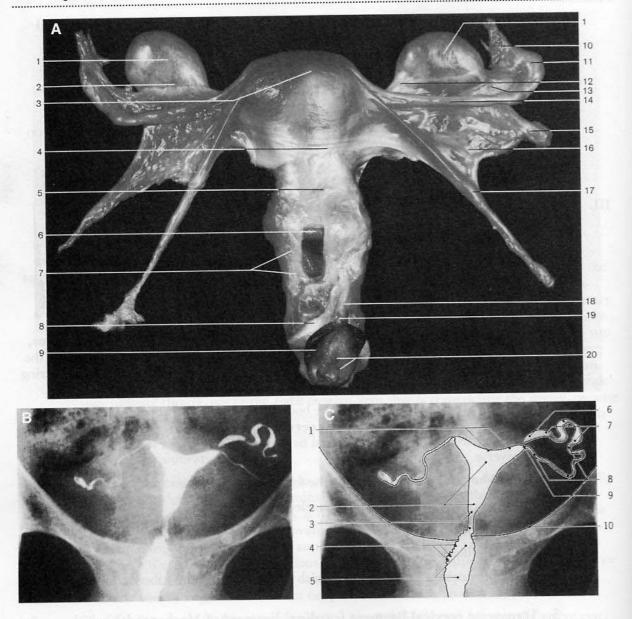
(*A*) Anterior view of the female genital organs, with the anterior wall of the vagina opened to show the cervix. 1 = ovary; 2 = mesovarium; 3 = fundus of the uterus; 4 = vesicouterine pouch; 5 = cervix; 6 = vaginal part of the cervix; 7 = vagina; 8 = crus of the clitoris; 9 = labium minus; 10 = infundibulum of the uterine tube; 11 = ampulla of the uterine tube; 12 = ovarian ligament of the uterus; 13 = mesosalpinx; 14 = uterine tube; 15 = suspensory ligament of the ovary (caudally displaced); 16 = broad ligament; 17 = round ligament of the uterus; 18 = corpus cavernosum of the clitoris; 19 = glans of the clitoris; 20 = hymen (vaginal orifice). (*B*) Anteroposterior radiograph of the female genital tract (hysterosalpingography). 1 = fundus of the uterus; 2 = uterine cavity; 3 = isthmus of the uterus; 4 = folds of the cervix; 5 = cervical canal (dilated and stretched); 6 = infundibulum of the uterine tube; 7 = ampulla of the uterine tube; 8 = isthmus of the uterine tube; 9 = opening of the uterine tube; 10 = pecten of the pubis. (*A* reprinted with permission from Rohen JW, Yokochi C, Lütjen-Drecoll E: *Color Atlas of Anatomy*, 1 = tunion of the uterine sensition of the uterine of the pubis. (*A* reprinted with permission from Fleckenstein P, Tranum-Jensen J: *Anatomy in Diagnostic Imaging*. Philadelphia, WB Saunders, 1993, p 291.)
